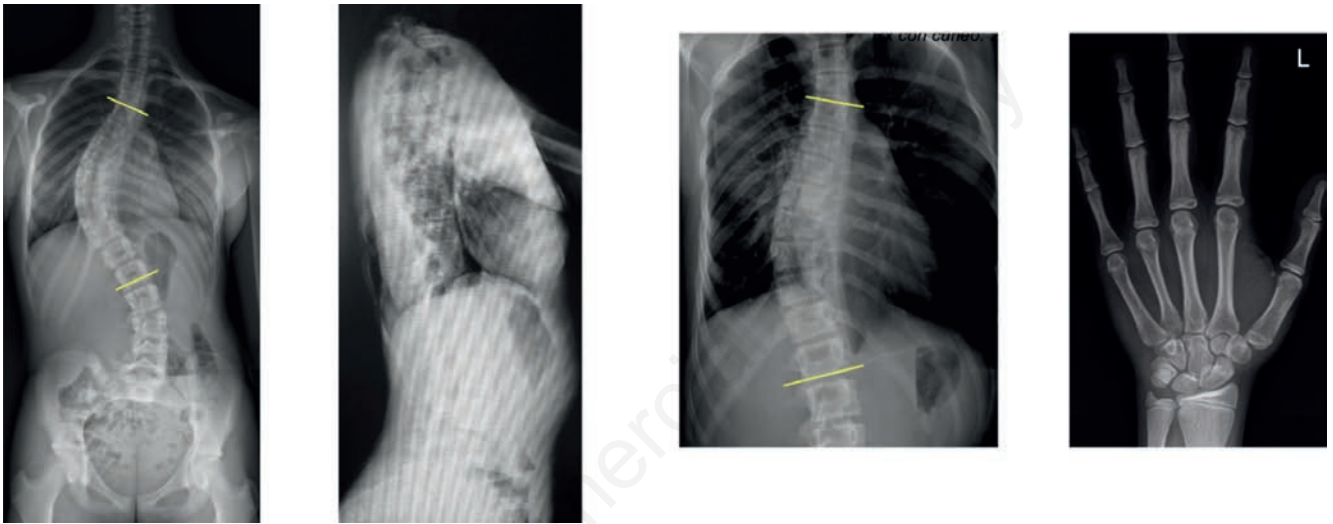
Female, 13 years old. Pre-operative X-rays: thoracic right convex curve Lenke 1A 55° Cobb, Risser 3, 20° Cobb on supine side bending, Risser 3, Sanders 4.
